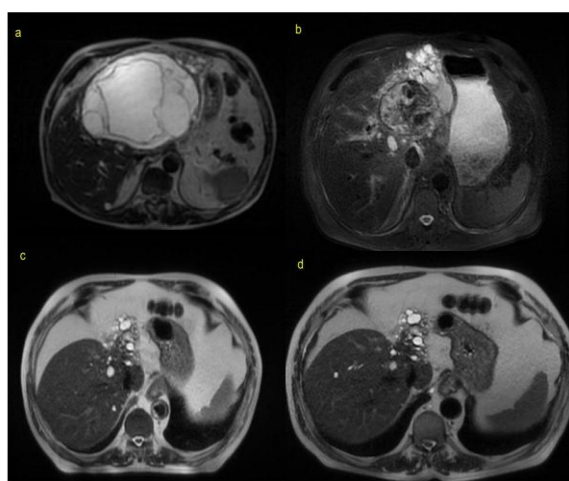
Changes in Hydatid Cyst Lesions over time (MRI)
